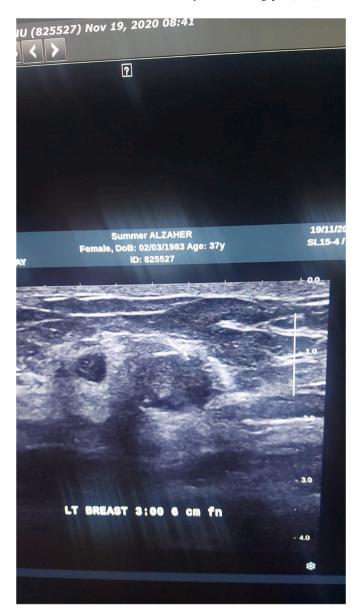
Ultrasonography of the breast showed granulomatous mastitis.
